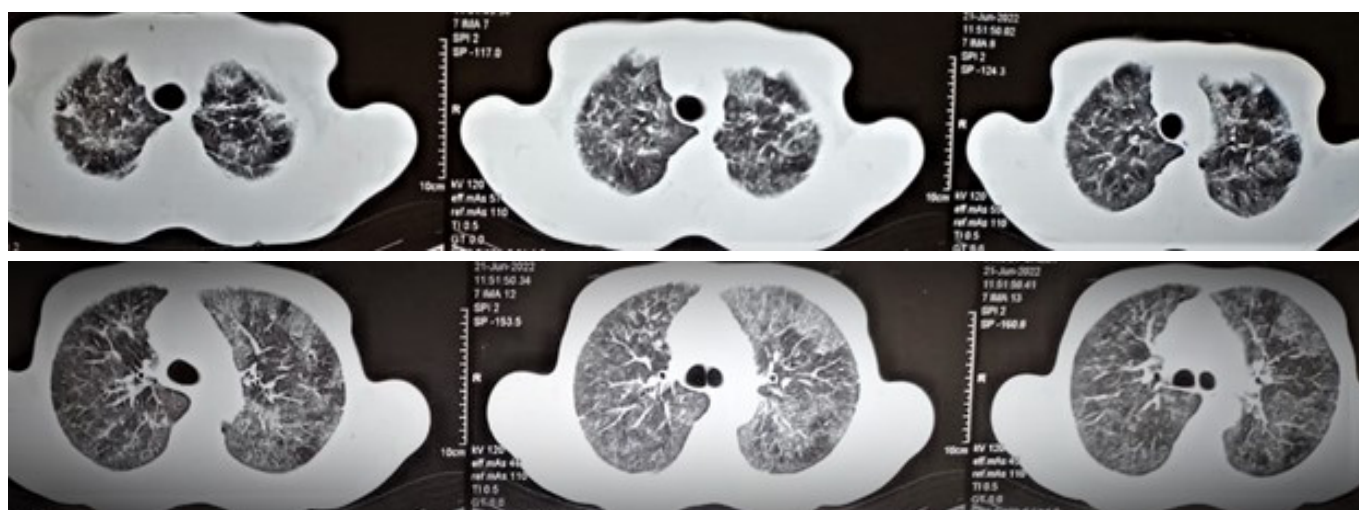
High Resolution Computed Tomography of chest of the same patient after 2 episodes of the lung lavage i.e., left upper lobe and the right lung lavage. The significant improvement in the left upper lobe opacity can be seen.
